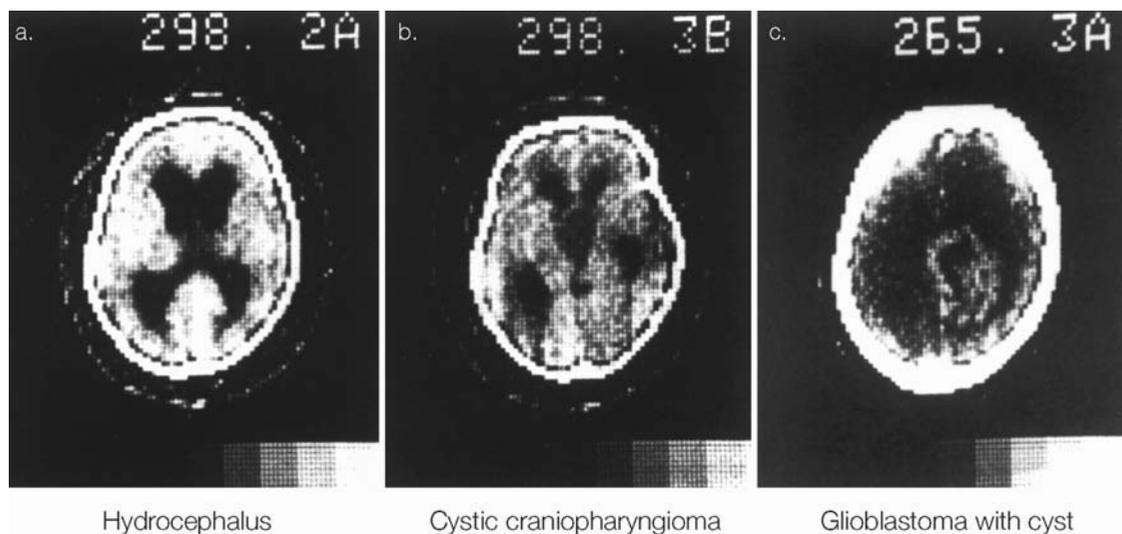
Some of the first examples of cranial computed tomography obtained in three patients with (a) hydrocephalus, (b) cystic craniopharyngioma and (c) glioblastoma
